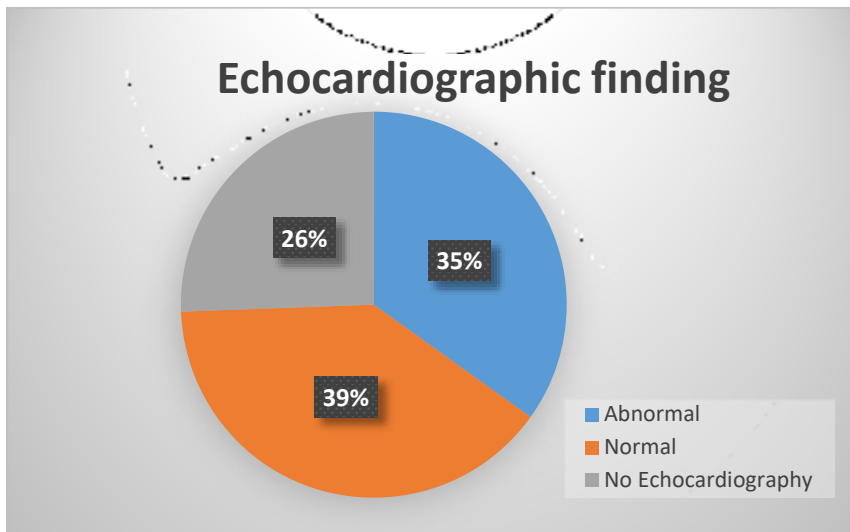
Finding of pre-transplant echocardiographic abnormalities (n=43)
